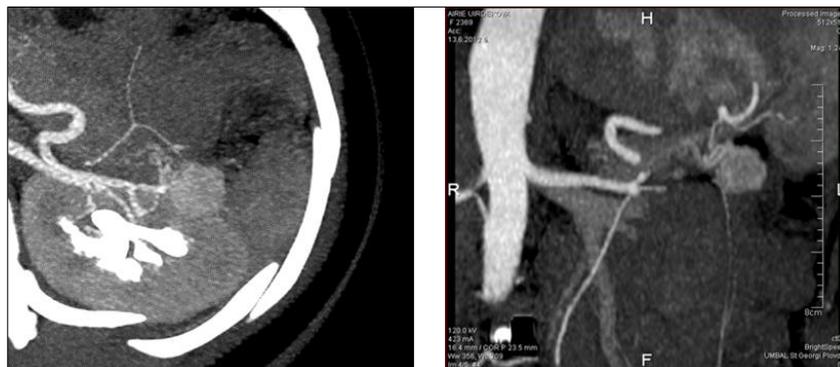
Helical CT of the upper abdomen
